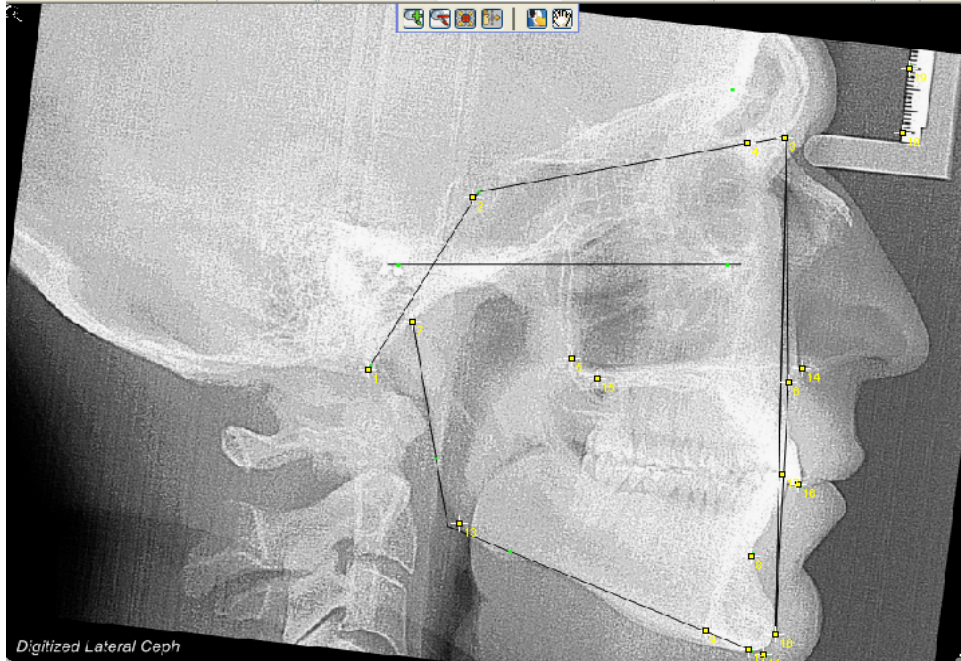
ImageJ traced lateral cephalometric radiograph
